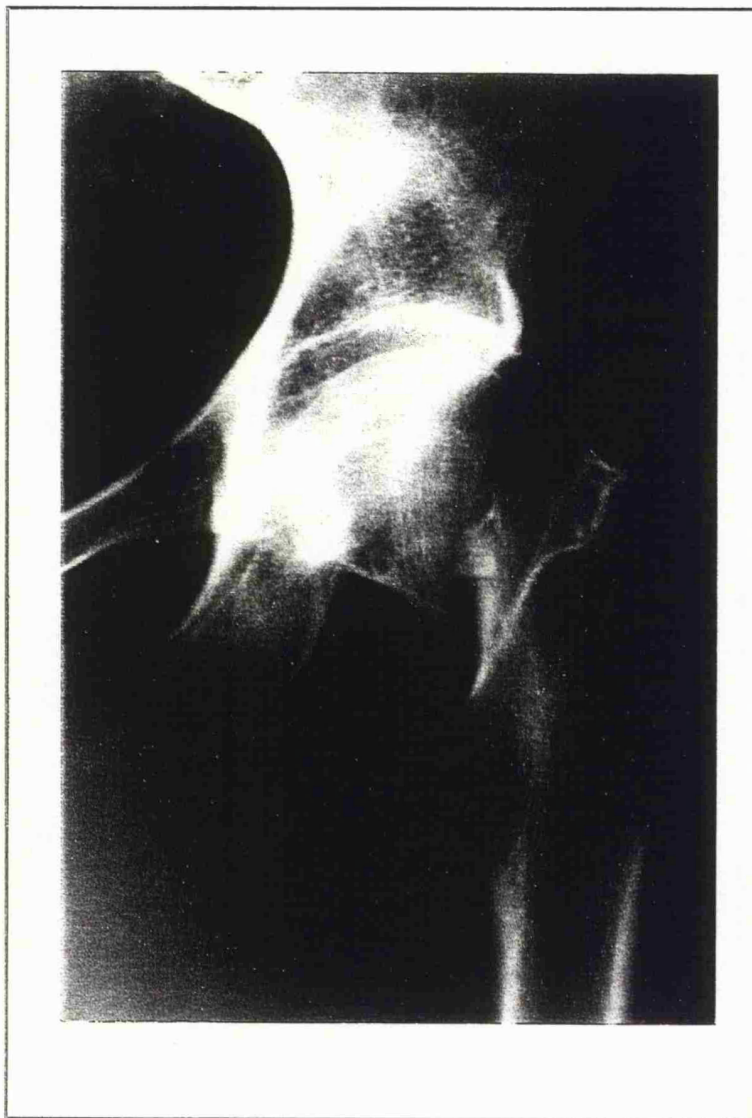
An antero-posterior radiograph of a Garden Stage IV fracture showing the femoral head rotated back into the anatomical position.
